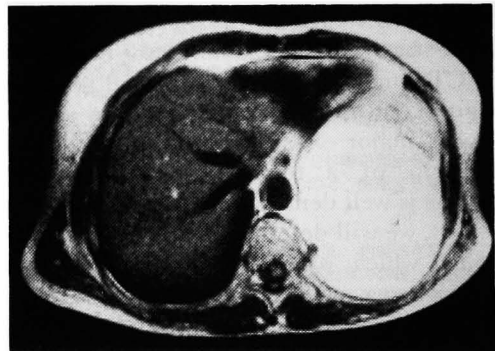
MRI in transverse view: A high intensity mass emerging from the left kidney is revealed in T<sub>1</sub> weighted imaging.
